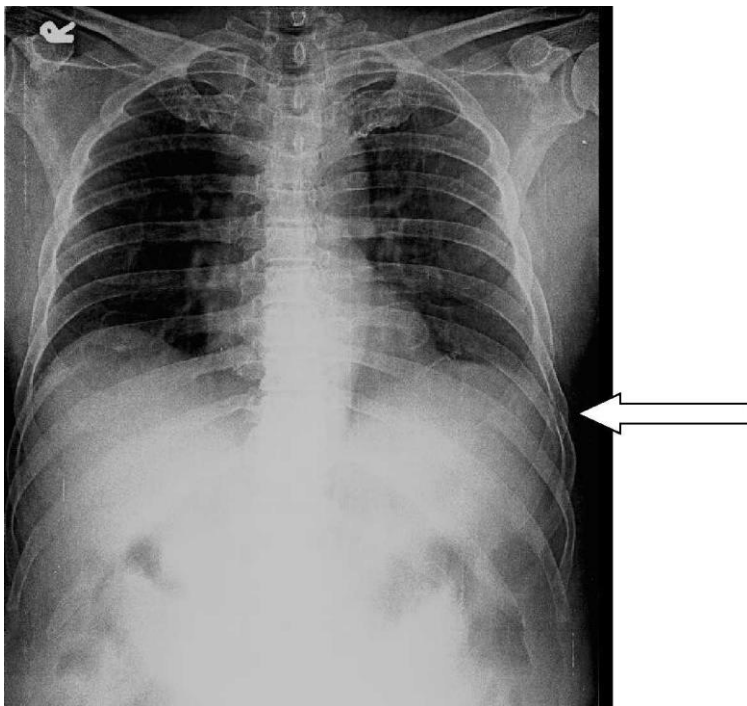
Frontal radiograph of the chest shows left 7th and 8th rib fractures
